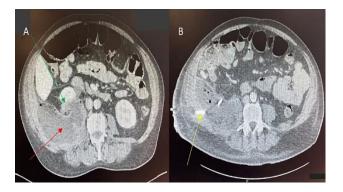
CT scan demonstrating (A) a large right iliopsoas abscess (red arrow) connecting to the lower posterior pole of the right kidney (green arrow), and (B) repeat CT scan imaging showing a retroperitoneal drain in situ (yellow arrow).
